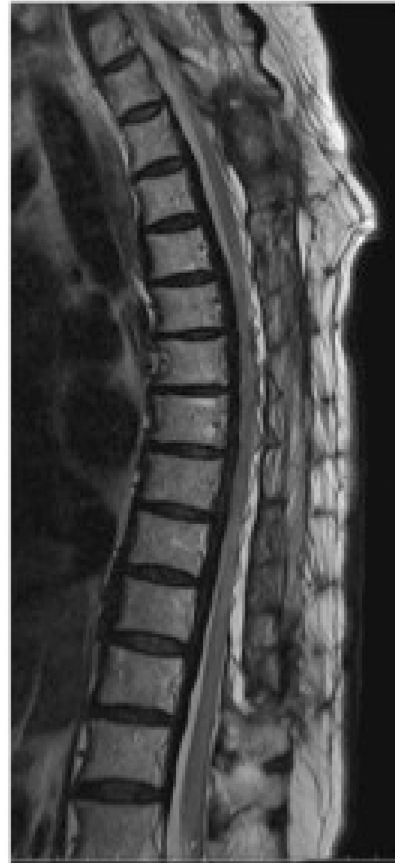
Postoperative sagittal view of spine MRI showing A) T1-weighted image, and B) T2-weighted image. Spinal atrophy was improved.
